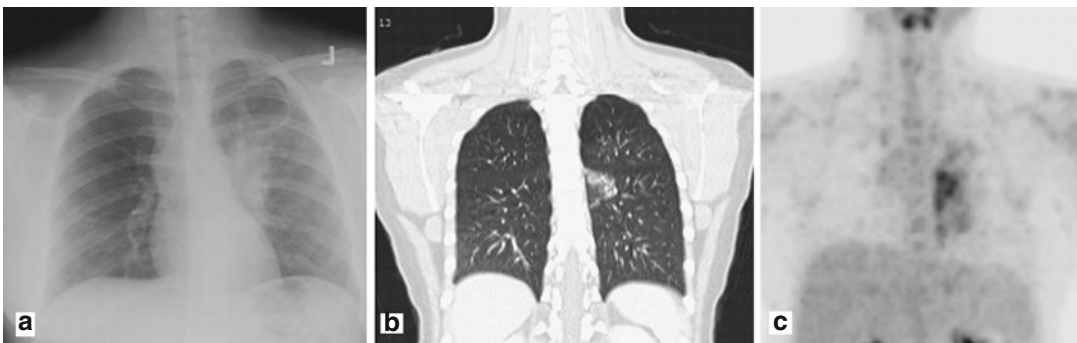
^{18}F -FDG uptake in pneumonia. A 13-year-old girl following chemotherapy and radiation therapy for Hodgkin's lymphoma presented with 5 days of fever and cough. (a) The chest X-ray revealed left lower lobe pneumonia. (b) A selected coronal computed tomography
